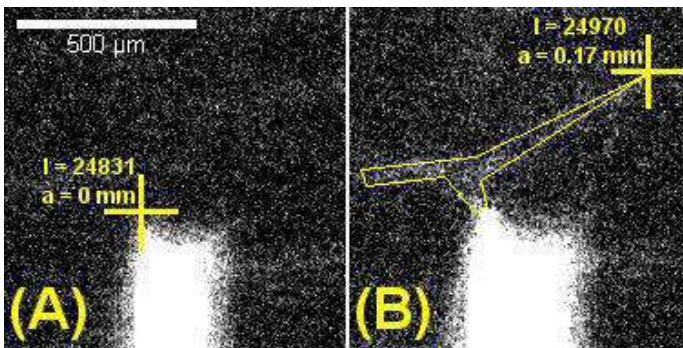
2D x-ray images of bone under loading at (A) beginning of load and (B) after stable crack growth. Markers depict crack tip identification via intensity ( $I$ ).
